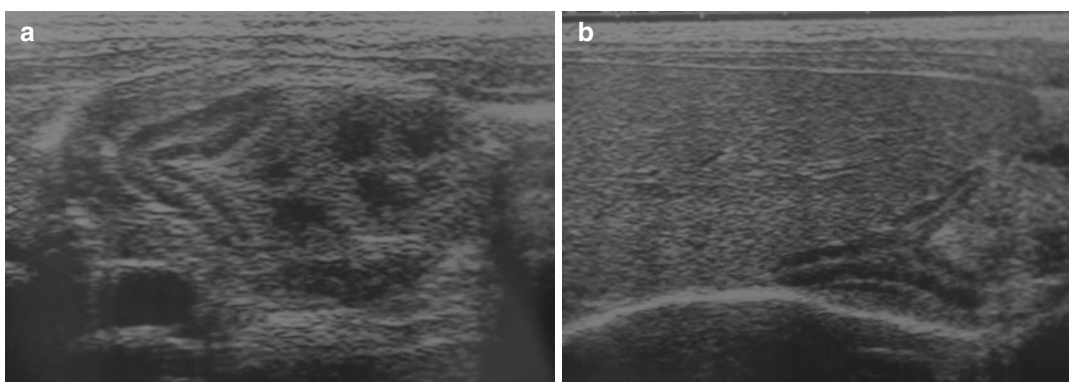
Sonographic aspects of normal adrenal glands in newborn. (a) Right adrenal gland, V shape. (b) Left adrenal gland, Y shape
